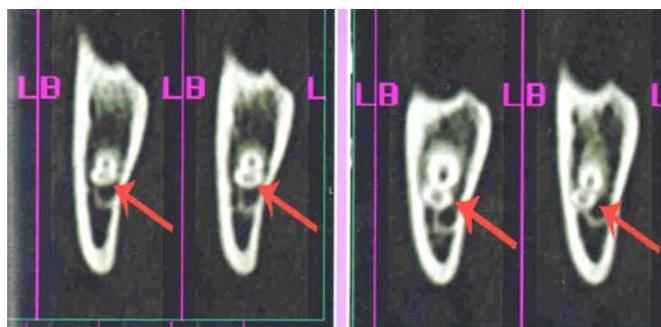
Direct coronal CT image depicting intimate relationship between mandibular third molar and mandibular canal
